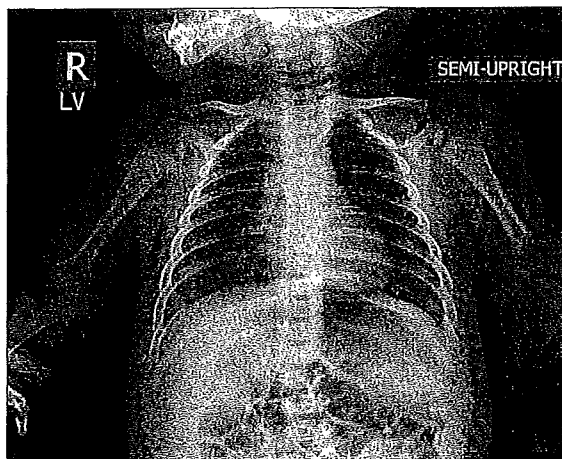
Chest radiograph of infant who has respiratory syncytial virus bronchiolitis, demonstrating hyperinflation and small areas of patchy, bilateral atelectasis.
